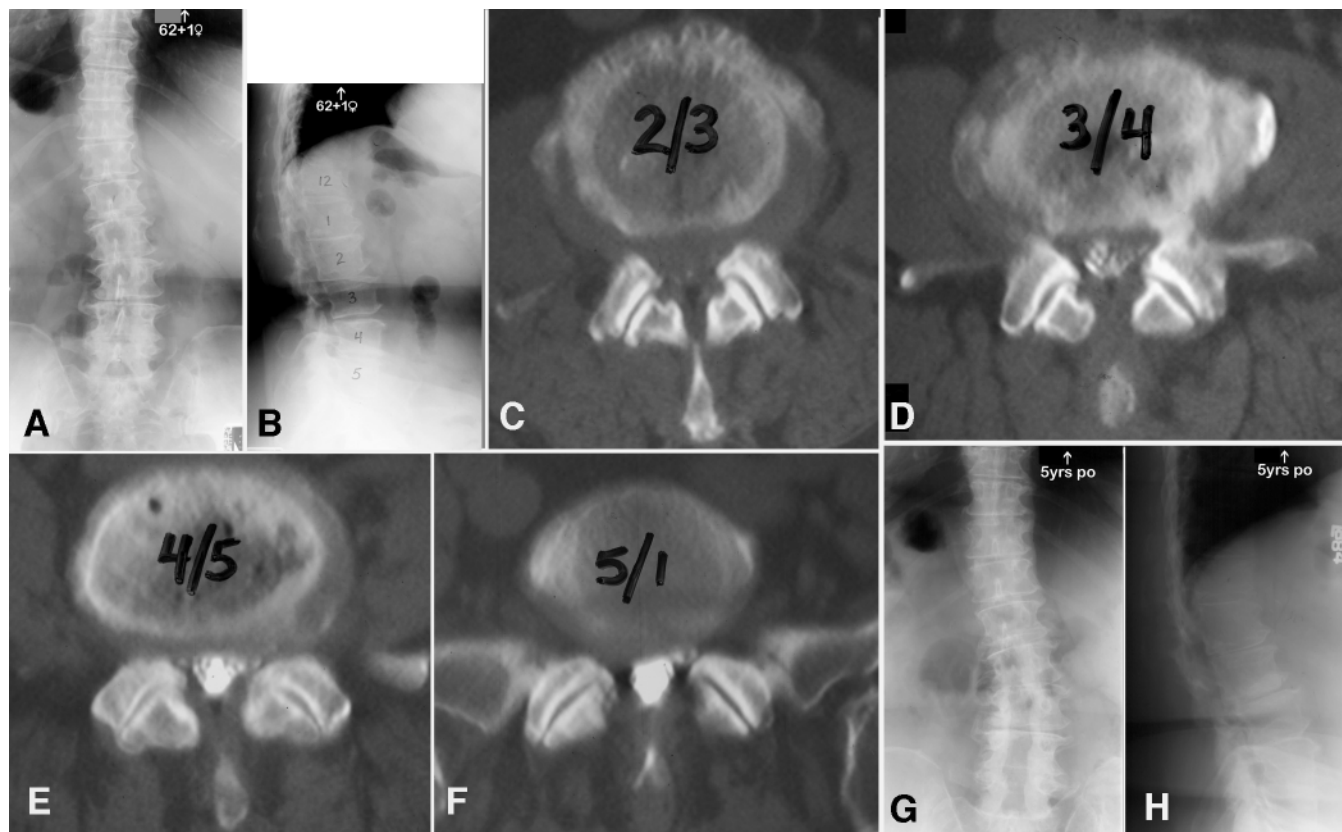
Lenke-Silva Treatment Level I. A and B: Images obtained in a 62-year-old male with neurogenic claudication. C–F: Computed tomography myelograms of L2–3, L3–4, L4–5, and L5–S1 showing spinal stenosis. G and H: Five-year postoperative radiographs demonstrating maintained alignment from L2 to the sacrum.
